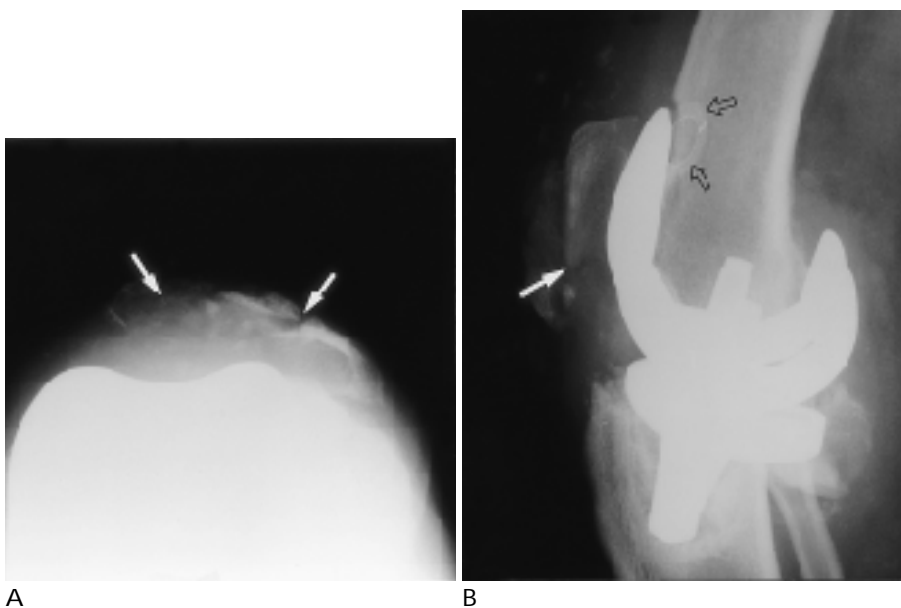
A 55-year-old man with patellar fracture at 2 years after TKA. A. The skyline radiograph shows patellar fracture and fragmentation(arrows). B. The lateral radiograph shows patellar fracture(arrows) accompanied by patellar component displacement(open arrows).
